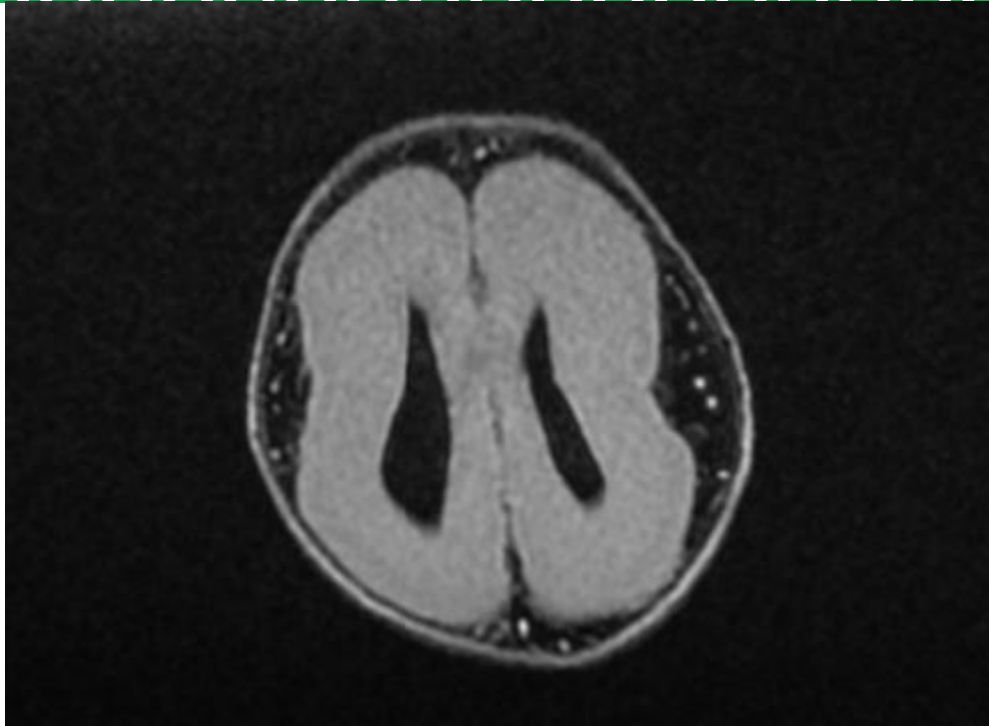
(a-b) Brain MRI to 5 days of life: a) T2 sagittal sequence b) T1 sagittal sequence
